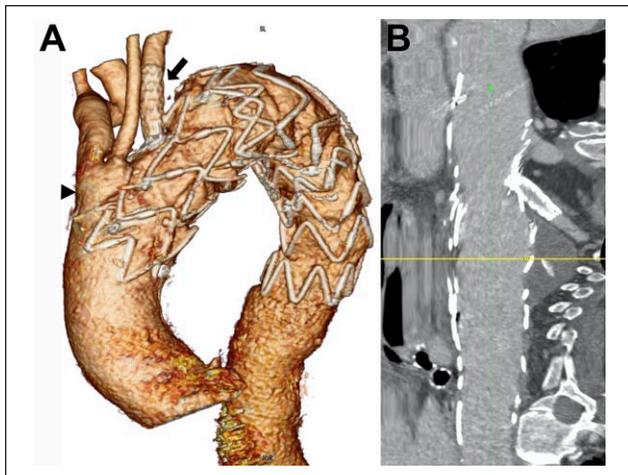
(A) Volumetric rendering and (B) reconstruction following the center lumen line after implantation of the physician-modified stent-graft. The linear high attenuation signal in the aneurysm sac is atherosclerotic plaque, which was seen on pretreatment computed tomography angiography and non-enhanced scans. The arrow in A points to the bridging stent through the fenestration, while the arrowhead identifies the common origin of the innominate and left common carotid arteries surrounded by the scallop.
